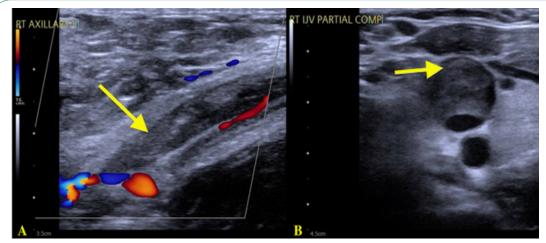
On postoperative day 13, the patient developed right upper extremity pain and swelling. Venous Doppler ultrasound of the region was notable for acute obstruction (arrow) of the axillary vein (A) and obstruction of indeterminate age (arrow) in the right internal jugular vein (B).
